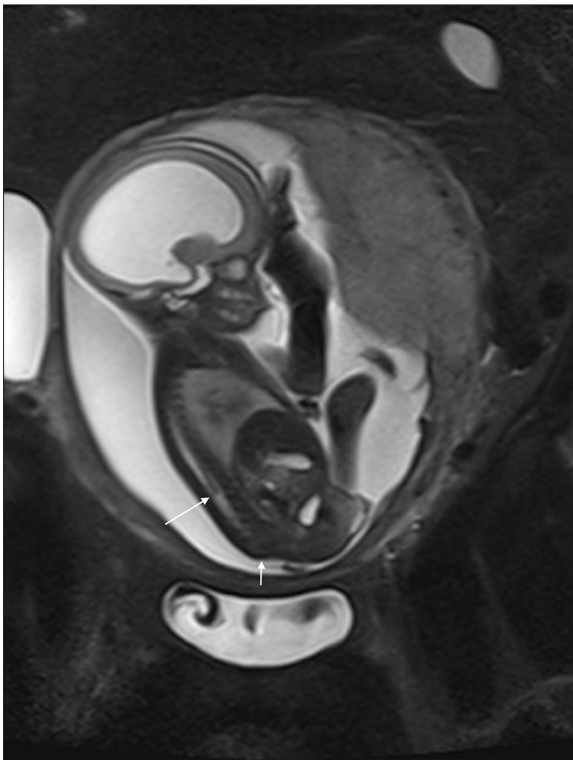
Fetal MRI of a 26-year-old primigravid woman with gestational diabetes shows sacral agenesis (smaller arrow) and a blunt-ending, club-shaped conus (larger arrow).
